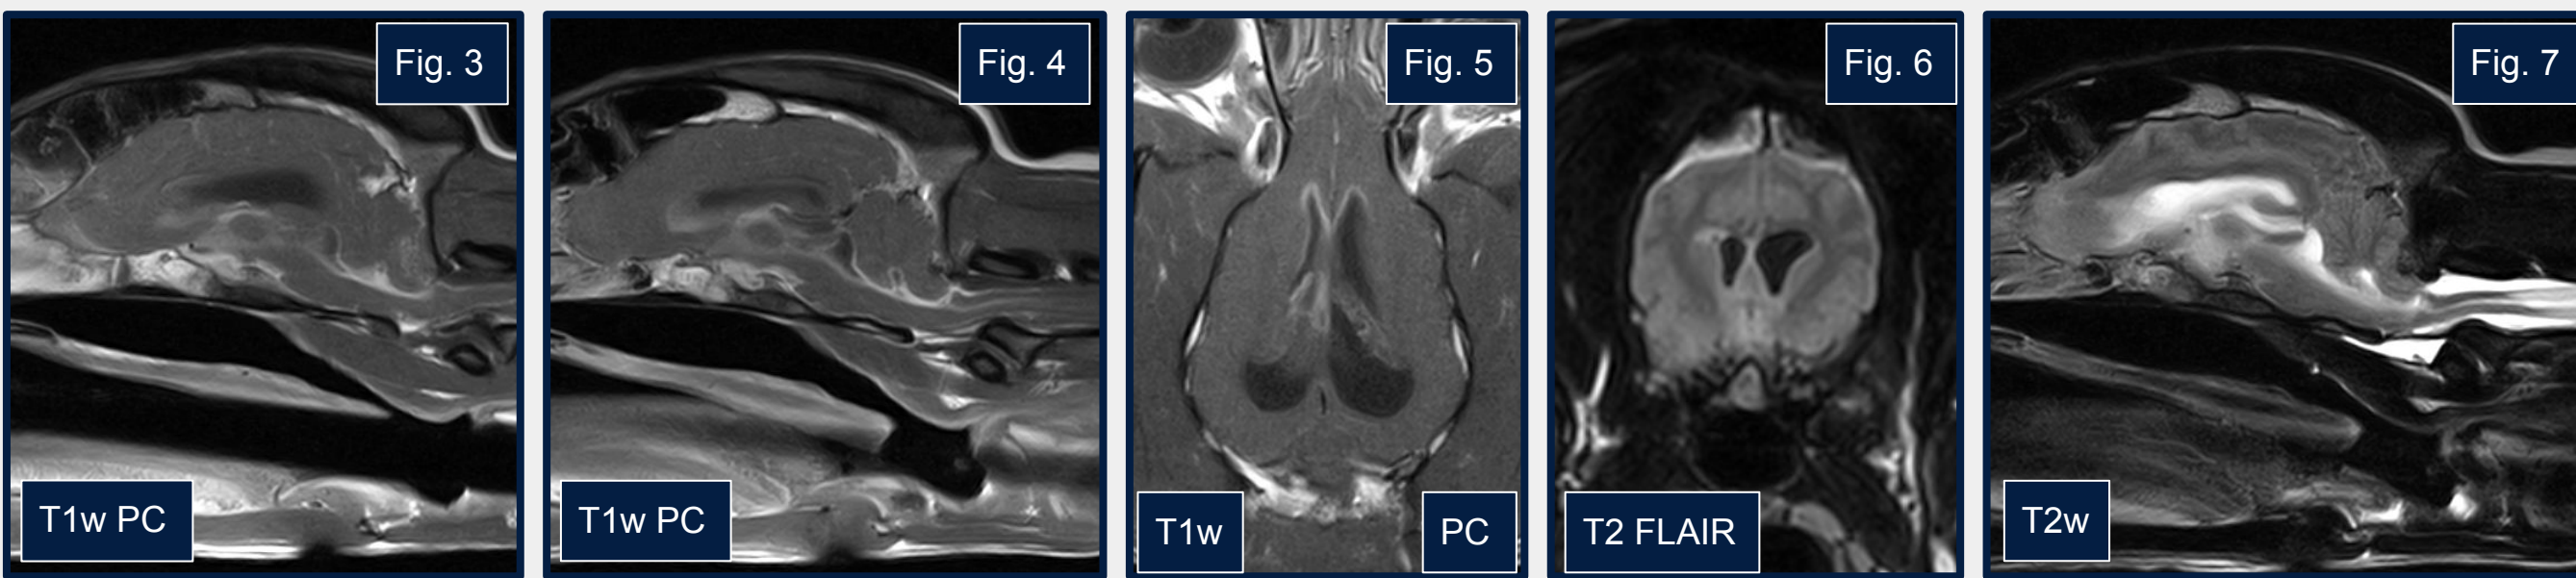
T2w & T2 FLAIR, showing increased periventricular hyperintensity.
